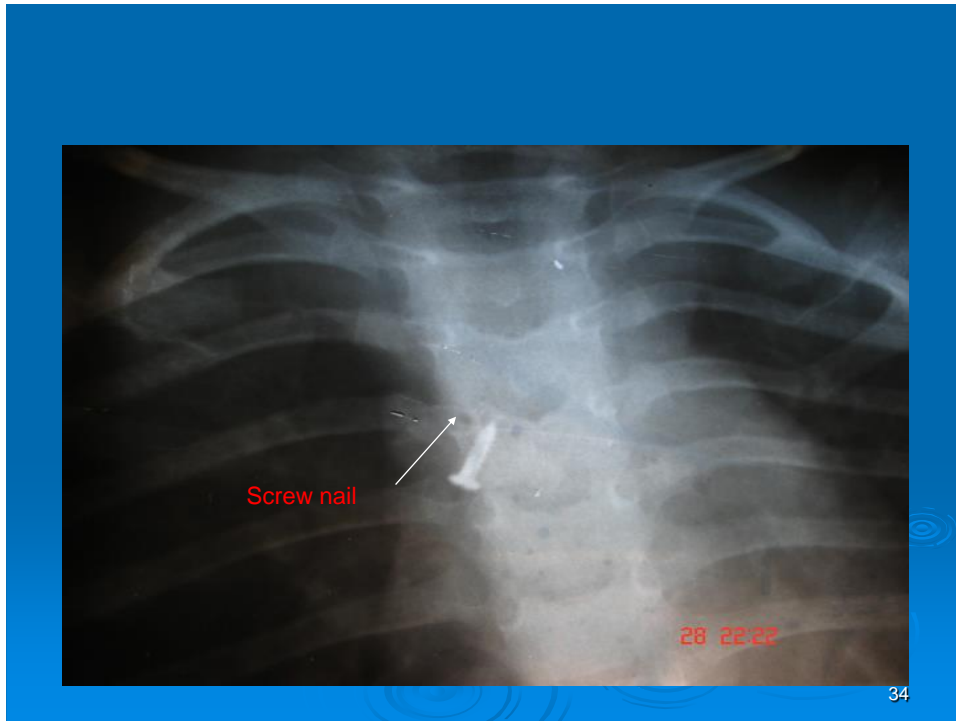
Bronchial foreign body. This x-ray anterior-posterior view; reveals a foreign body (screw nail); in the right main bronchus area.
